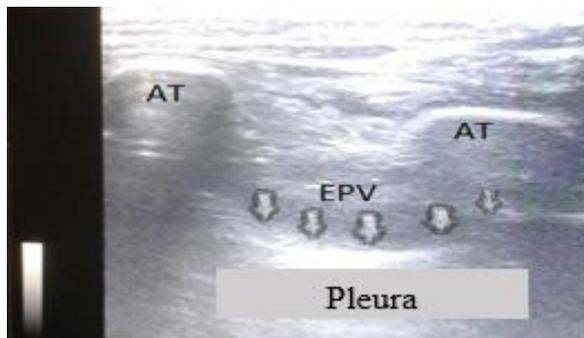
Ultrasound image showing the anterior displacement of the pleura after injection of serum physiology (hydro-dissection).
